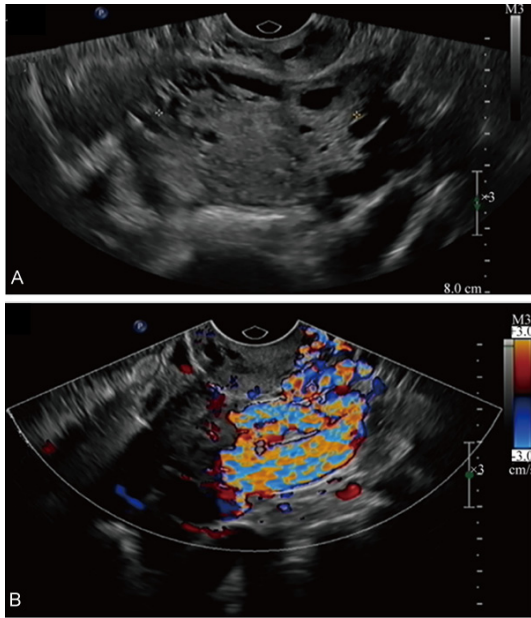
A. Transvaginal US image of the uterus showing multiple cystic structures of several sizes within the uterine myometrium. B. Transvaginal color Doppler sonography demonstrating a tangle of vessels with high-velocity, low resistance turbulent flow producing a color mosaic pattern.
